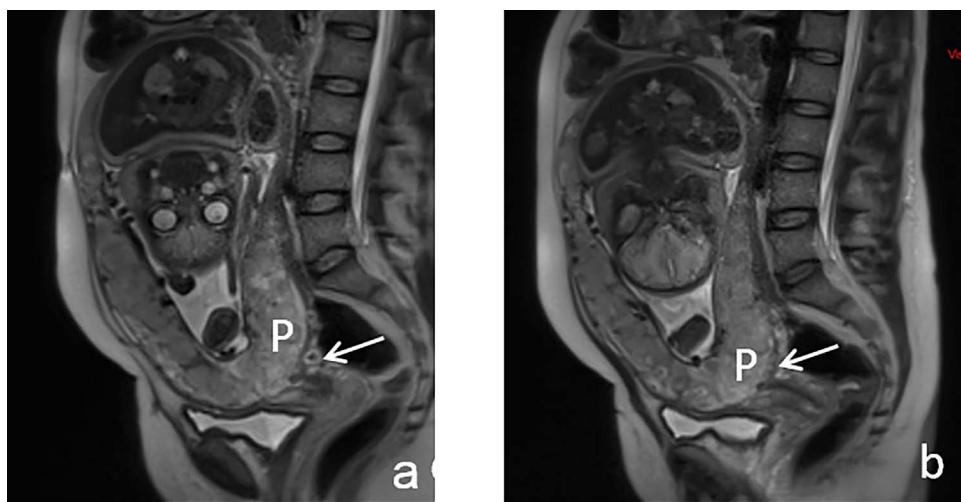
Placenta previa.- 39 y.o. patient with a prior cesarean delivery presenting with light vaginal bleeding at the 24th week of pregnancy. PP was detected at US. Complementary sagittal T2- W MR images (a, b) clearly show the placenta (P), entirely covering the internal uterine os (white arrows).
